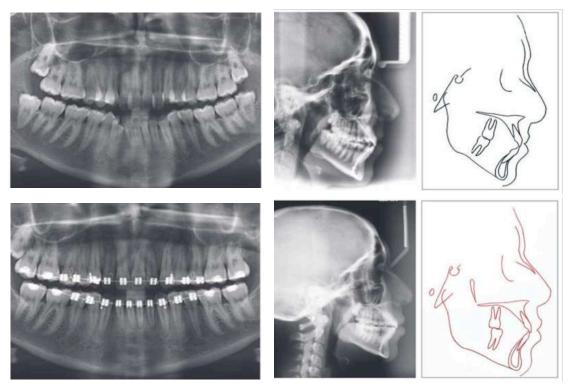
Comparison of X-Rays Images and cephalometric tracing before and after treatment.
